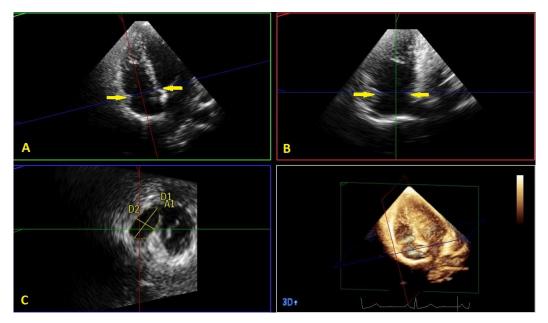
Medial-lateral (TV3D2) and anterior-posterior (TV3D1) diameters (white arrows in figures A and B) and cross-section area (figure C) of the tricuspid valve annulus (in en-face view, using 3D echocardiography are assessed
